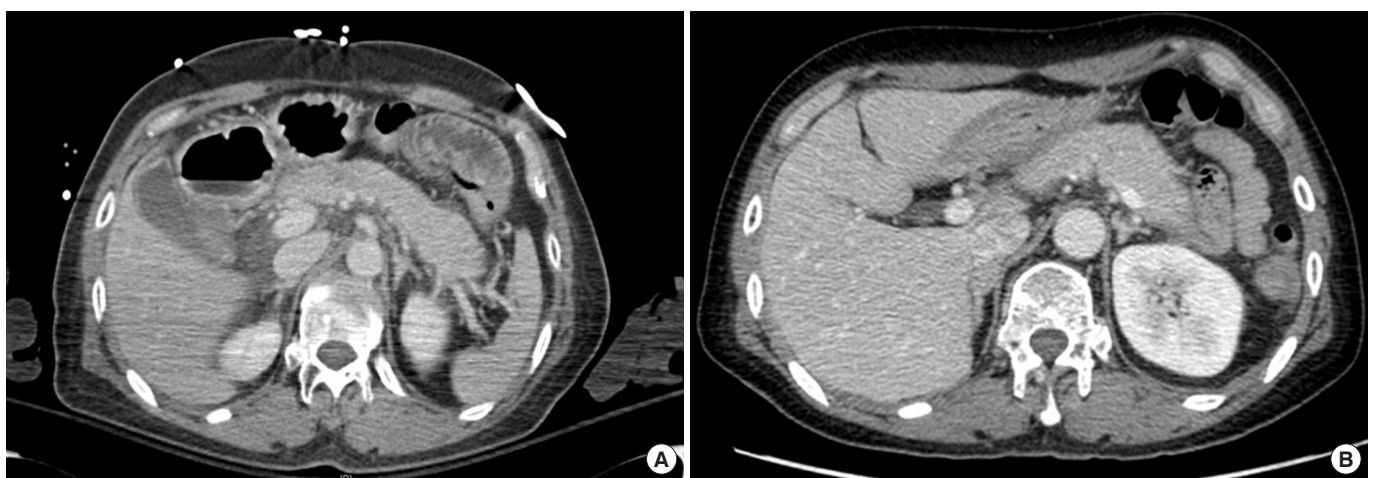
Abdominal computed tomography (CT) image of the pancreas showing diffuse swelling without necrosis or fluid collection. (A) Initial abdominal CT and (B) follow-up (7 days after admission) abdominal CT.
